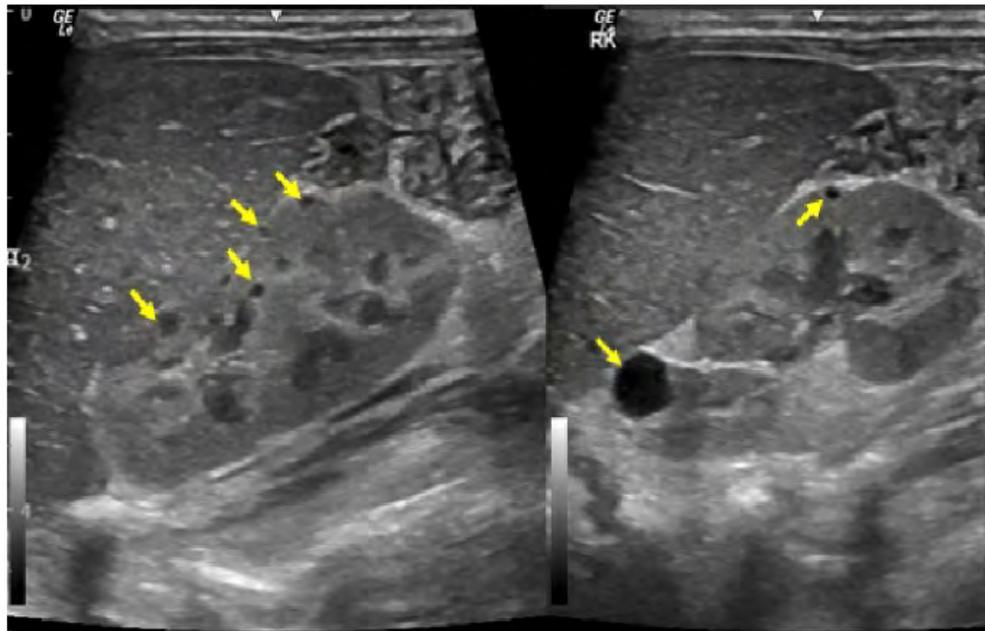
Ultrasound images of right kidney in the long axis.
